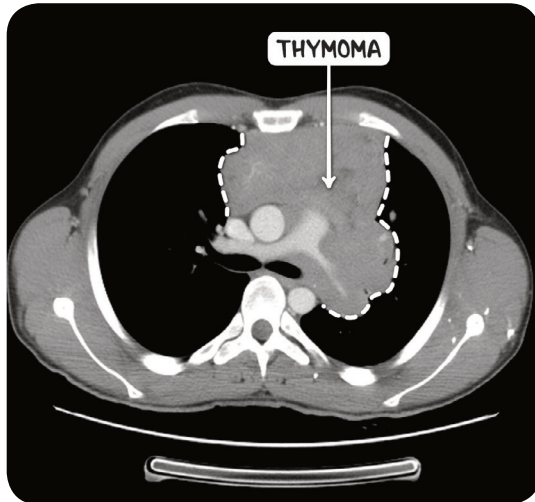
A CT scan in the axial plane demonstrating a large thymoma occupying the superior and anterior mediastinum.
